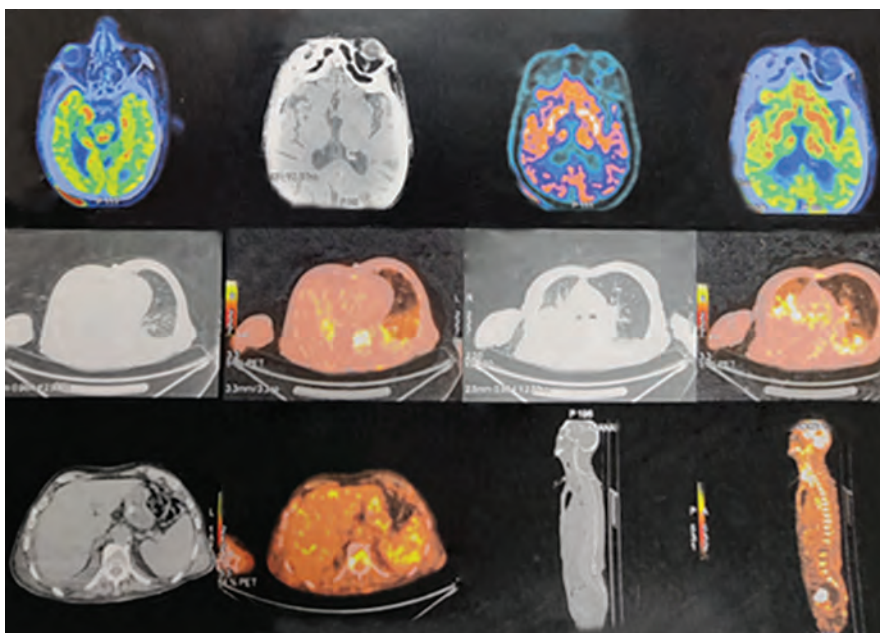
Whole body FDG PET-CT scan with brain PET-CT
